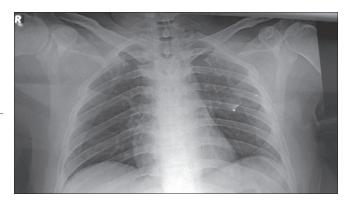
X-ray chest on the day of accident
